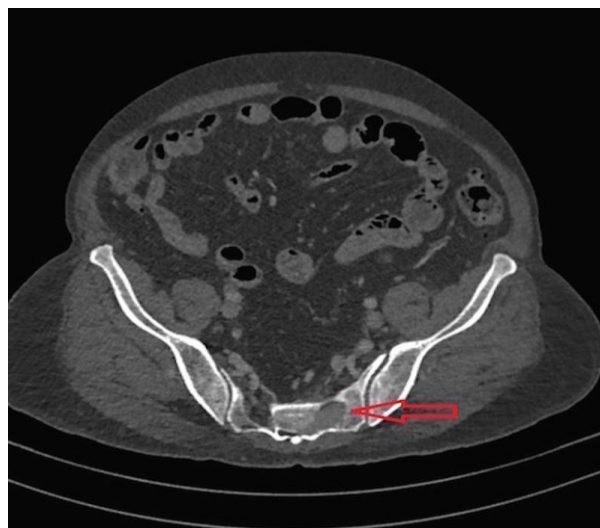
Axial bone window CT image showing a lytic lesion with soft-tissue component involving left-side of sacrum (marked with red arrow).
